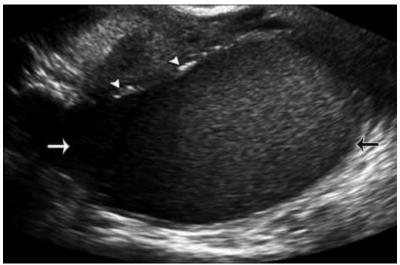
This is a transvaginal sagittal ultrasound image of an endometriosis history female patient in which overheads demonstrate multiple hyperechoic mural foci and arrows describing the ovarian mass having multiple precise internal echoes.
